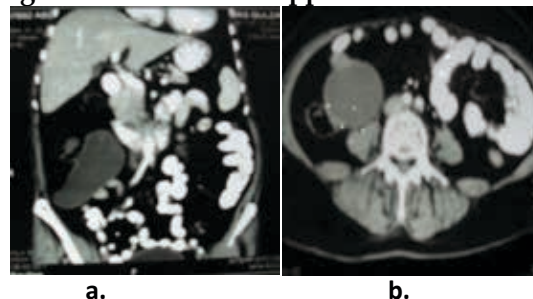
CT scan of mucocele of appendix.
